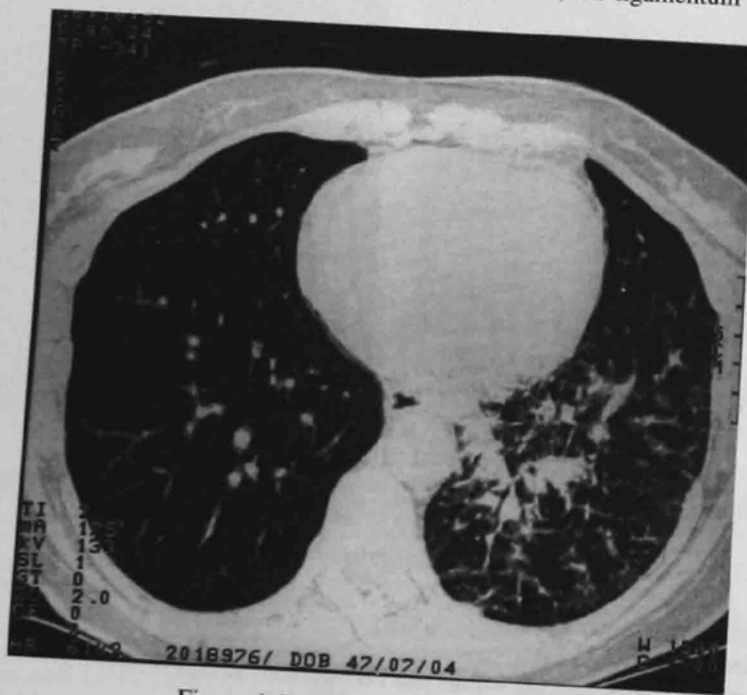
HRCT (lower lung zone)
